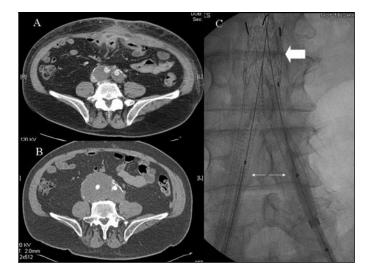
(A) CT scan four years after open AAA repair using a PTFE bifurcated graft. (B) Repeat CT (same level) eight years after open AAA repair when the patient presented with bilateral lower extremity edema. The previously patent IVC is compressed by a markedly enlarged aneurysmal sac. Delayed images demonstrated no IV contrast in the sac. (C) Endoconversion by relining. An aortic cuff (block arrow) was deployed below the renal arteries and stentgrafts (Viabohn) (arrows) were deployed inside the aortic cuff proximally and into the native iliac arteries distally.
